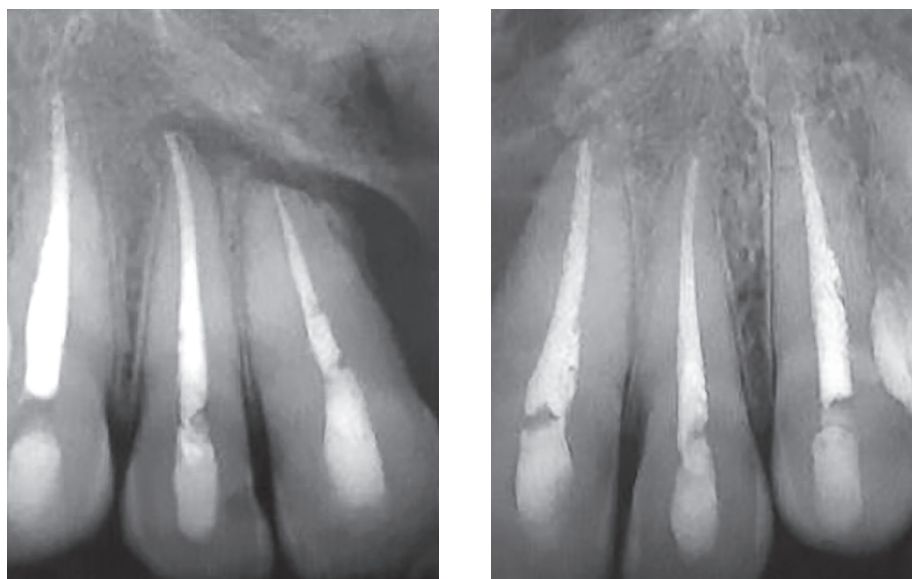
Radiographic images of examination performed two years after endodontic treatment.
